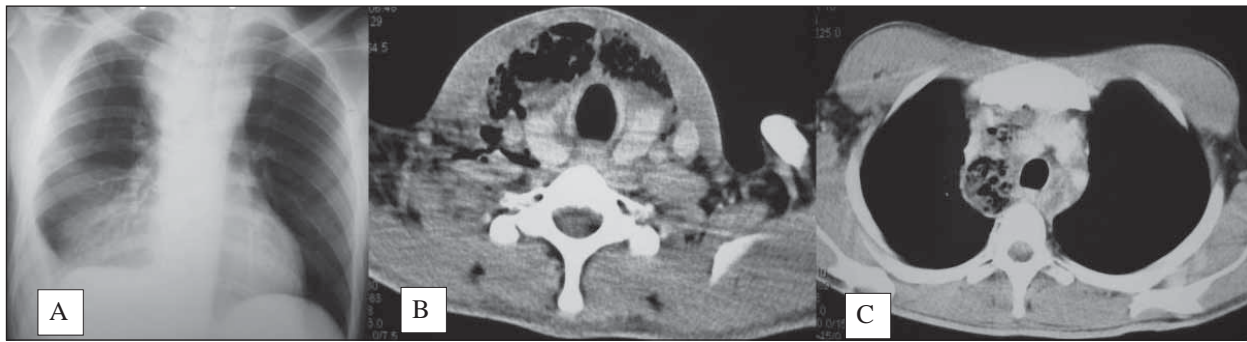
Preoperative Chest X-Ray and CT images showing the pleural effusion and the necrotizing infection on the neck and mediastinum
